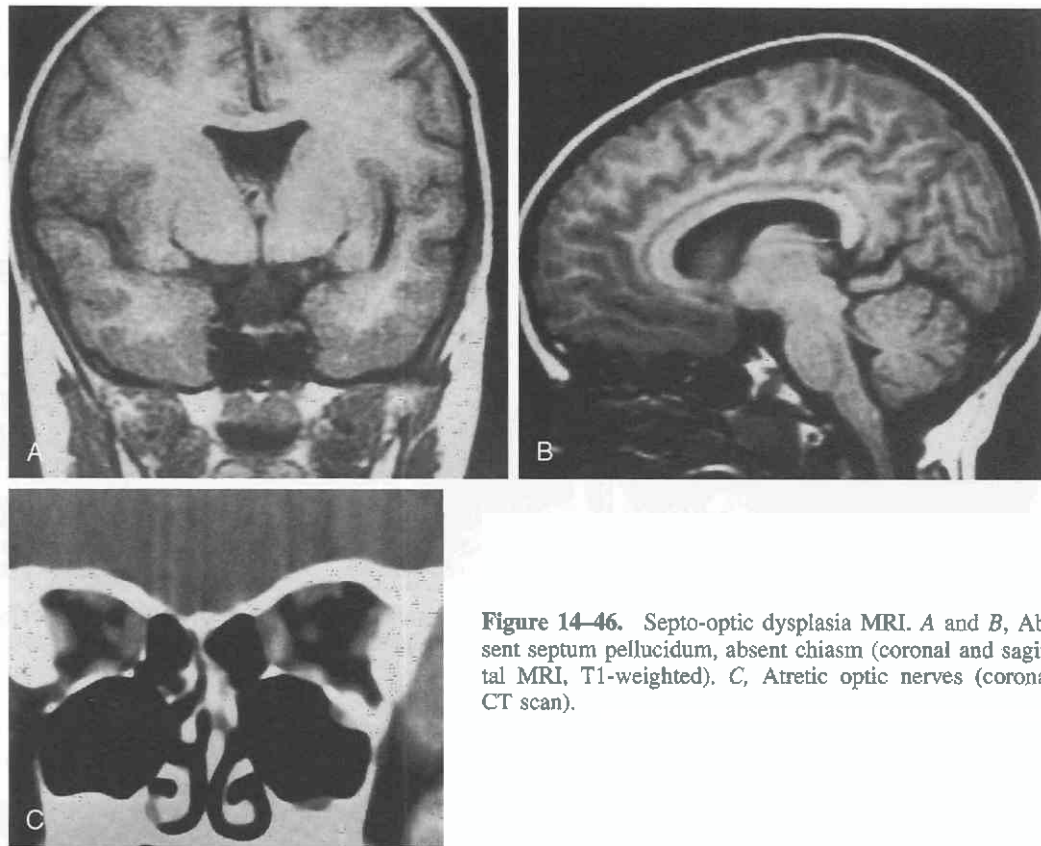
Septo-optic dysplasia MRI. A and B, Absent septum pellucidum, absent chiasm (coronal and sagittal MRI, T1-weighted). C, Atretic optic nerves (coronal CT scan).
